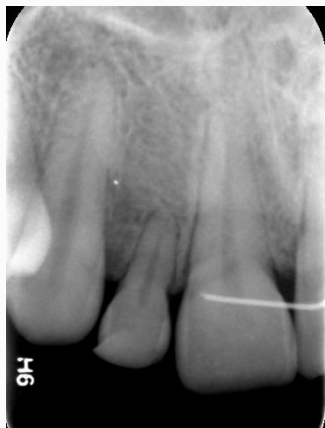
Pre-operative radiograph: Radiograph of maxillary left lateral incisor showing short clinical root.
